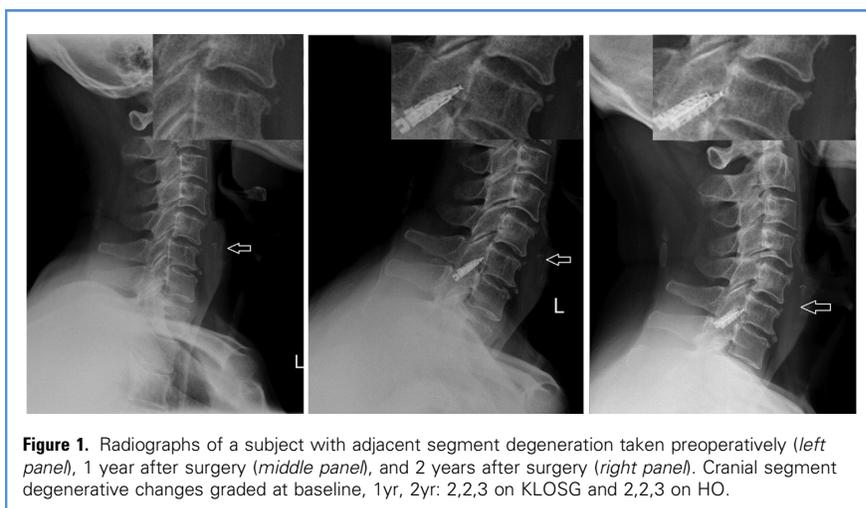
Radiographs of a subject with adjacent segment degeneration taken preoperatively (left panel), 1 year after surgery (middle panel), and 2 years after surgery (right panel). Cranial segment degenerative changes graded at baseline, 1yr, 2yr: 2,2,3 on KLOGS and 2,2,3 on HO.
